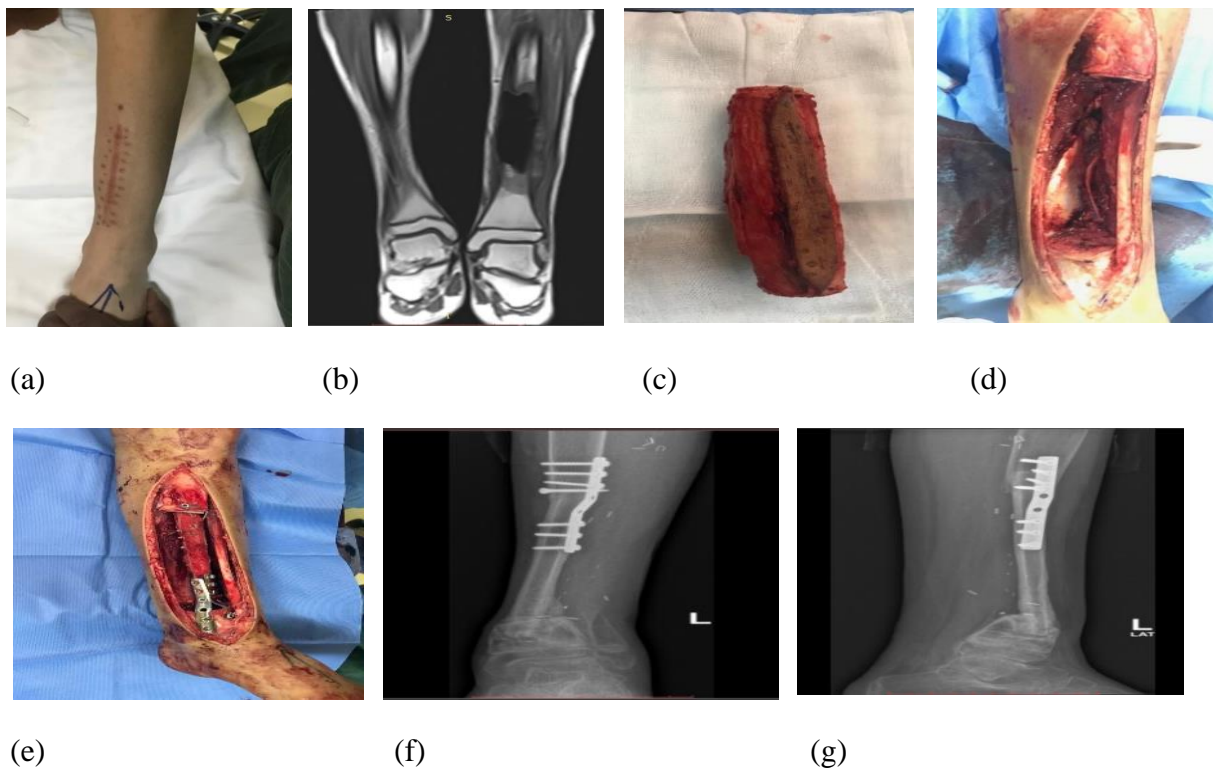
(a) 13 years old male with osteosarcoma of the left distal tibia (b) MRI image showing tumor of the left distal tibia (c) Gross picture of 14 cm excised tumor (d) Intraoperative image of the defect (e) Intraoperative image after fixation of the vascularized fibula as a single barrel with plates and screws (f) & (g) Anterior and lateral view of X-ray left tibia after 8 months of reconstruction showing the union of bones.
